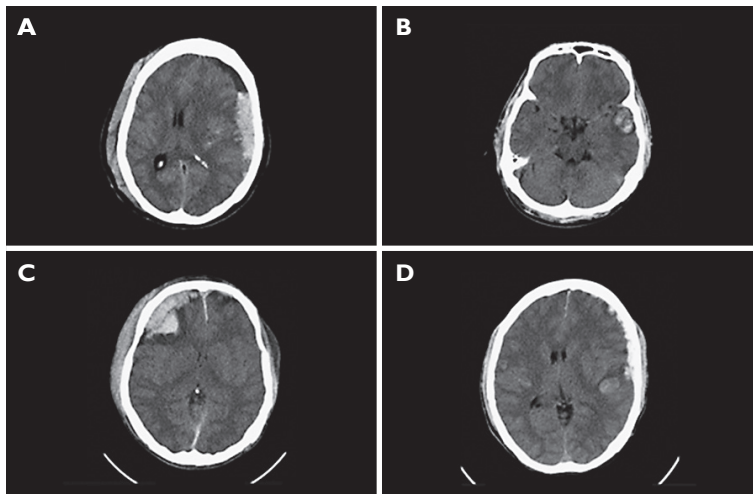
Subject's head CT-scan section samples (A – female, 53-years-old, RTS 6, greater intracranial haemorrhage volume, outcome: death < 24 hours; B – male, 32-years-old, RTS 12, less intracranial haemorrhage volume, outcome: alive; C – male, 20-years-old, RTS 11, greater intracranial haemorrhage volume, outcome: death in 3 days; D – male, 40-years-old, RTS 11, less intracranial haemorrhage volume, outcome: death in 8 days).
